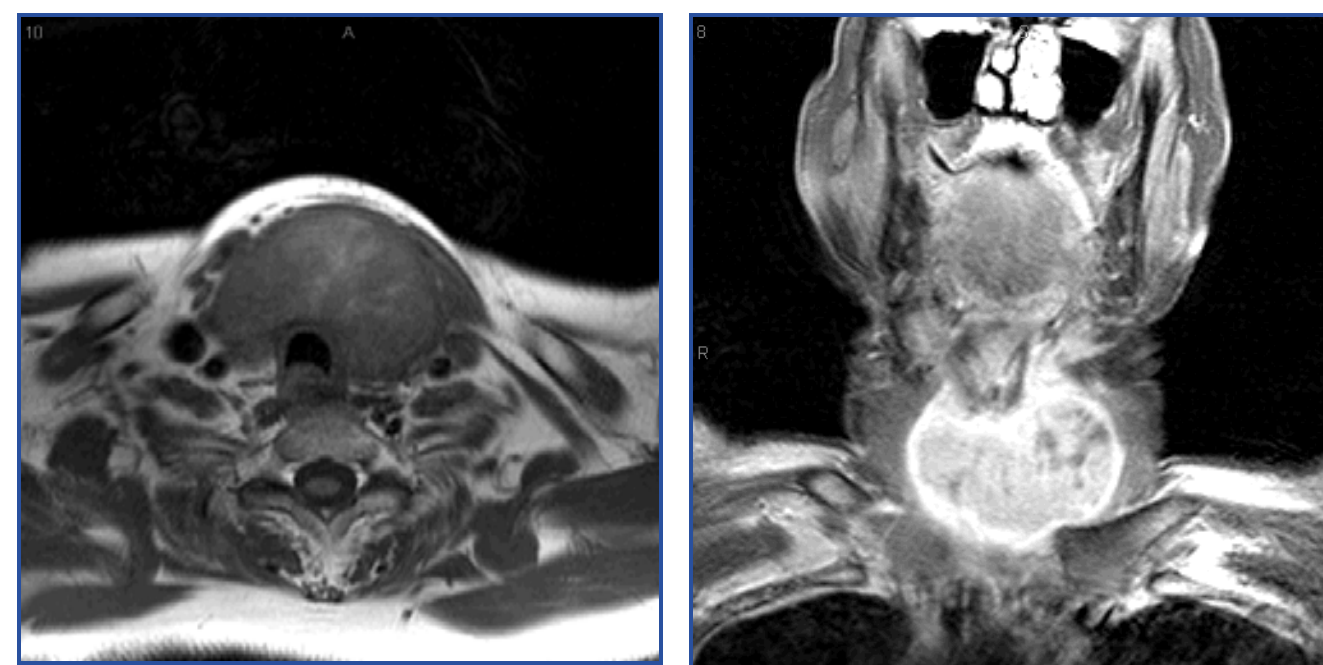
a) Axial T1W MRI showing enlarged thyroid gland, b) Coronal T2W MRI showing similar findings.
